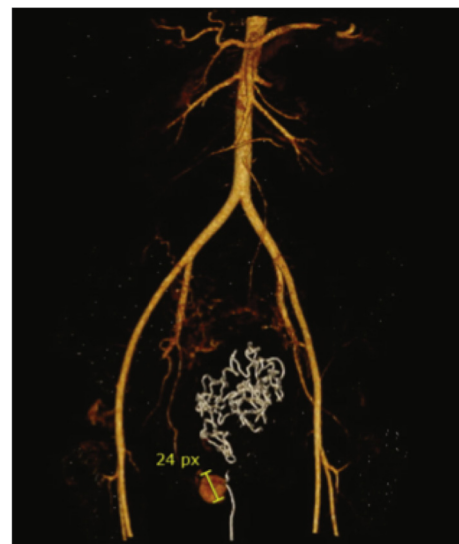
Repeat CT angiography demonstrating a pseudoaneurysm on a branch of the anterior division of the right internal iliac artery.
